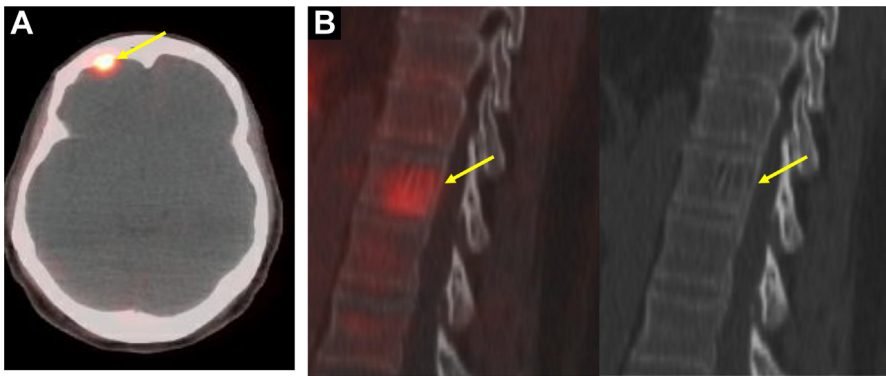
(A) Arrow points to focal ^{68}Ga -DOTATATE uptake in the right frontal bone, corresponding to a benign meningioma. (B) Arrow points to mild focal ^{68}Ga -DOTATATE uptake in a vertebral body lesion, with a classic “corduroy” appearance on CT, consistent with a benign hemangioma.
